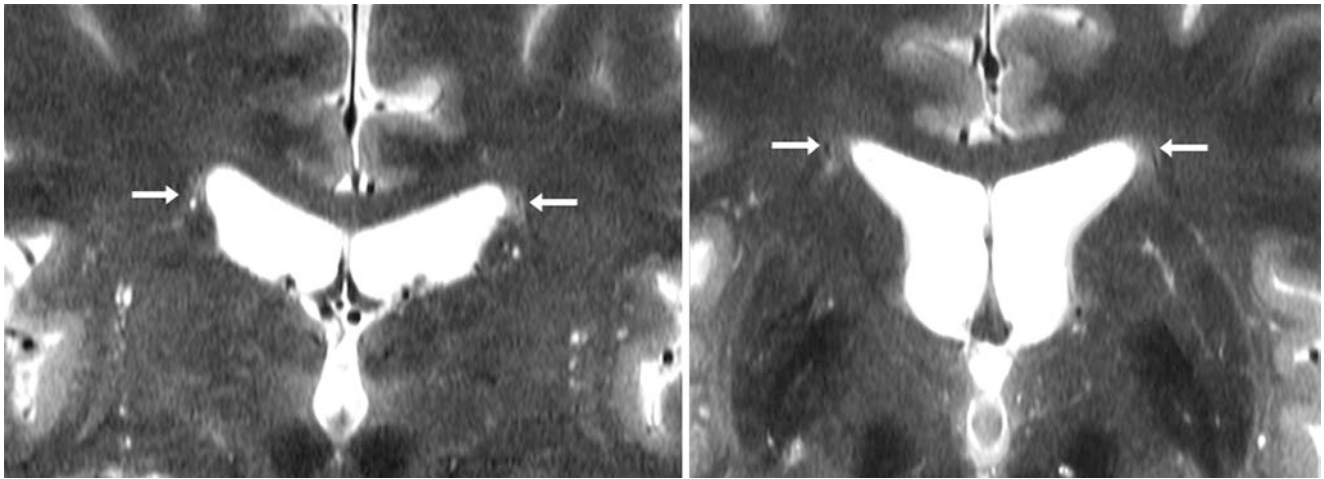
A 50 year old volunteer with 7 T MRI coronal T2WIs showing a left PEP (*arrows*); similar periependymal hyperintensity is present to a lesser degree on the right side. Additionally, note the multiple, incidental, tiny dilated perivascular spaces located diffusely throughout the basal ganglia
